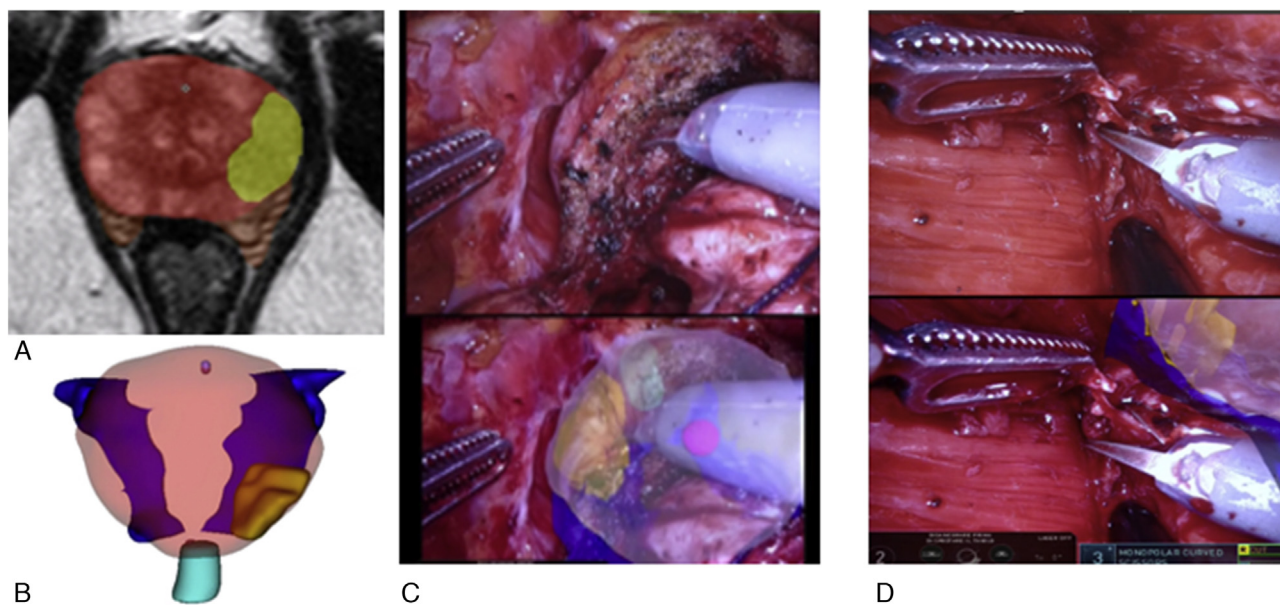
Example of AR-3D guided surgical dissection for real-time assessment of the index lesion during the nerve-sparing RARP through TilePro visualization and AR-3D guided IFS analysis. (A) A 17-mm left posterolateral apical index lesion PI-RADS v.2 score 5 (yellow area) is detected by mpMRI (Gleason score 3+4 in six cores at fusion-targeted biopsy). (B) The 3D model is employed with reconstruction of the index lesion (yellow), prostate glands (pink), urethra (light blue), and neurovascular bundles (blue). (C) AR-3D guided RARP with IFS analysis targeted to the projected index lesion was performed. (D) A first sample of the posterolateral periprostatic tissue is taken for IFS analysis at the level of the index lesion guided by AR. The first frozen section was found to be negative for tumoral cells; thus, the surgeon performed a grade 2 nerve sparing on the left side, modulating the dissection in real time, avoiding a plane of dissection too close to the level of the index lesion. AR=augmented reality; 3D=three dimensional; IFS=intraoperative frozen section; mpMRI=multiparametric magnetic resonance imaging; PI-RADS=Prostate Imaging Reporting and Data System; RARP=robot-assisted radical prostatectomy.
